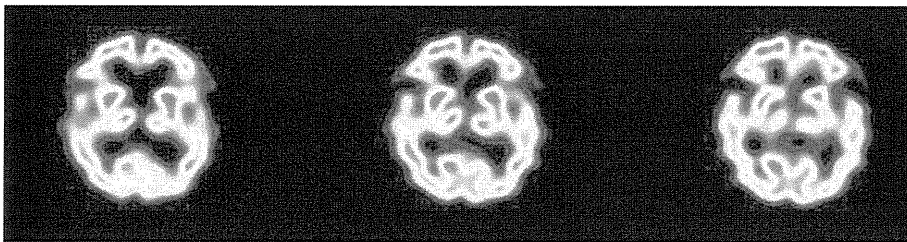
Normal uptake of the basal ganglia in ECD SPECT.
